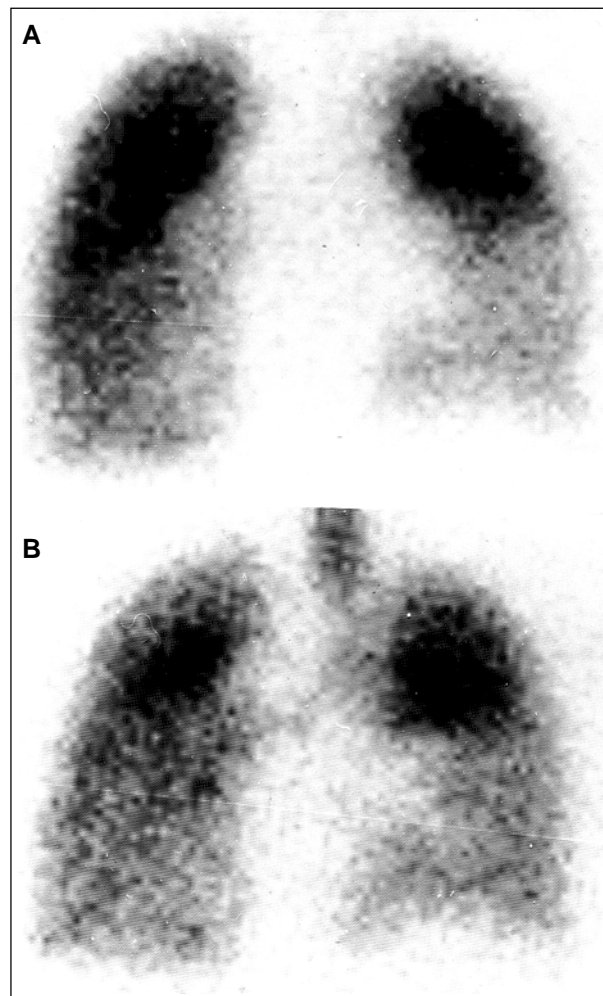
Pulmonary perfusion scintigraphy (fig. 3A) showing hypoperfusion in the right lung lower lobe similar to the pattern found in ventilation scan (fig. 3B), where hypoventilation of the same region may be seen.
